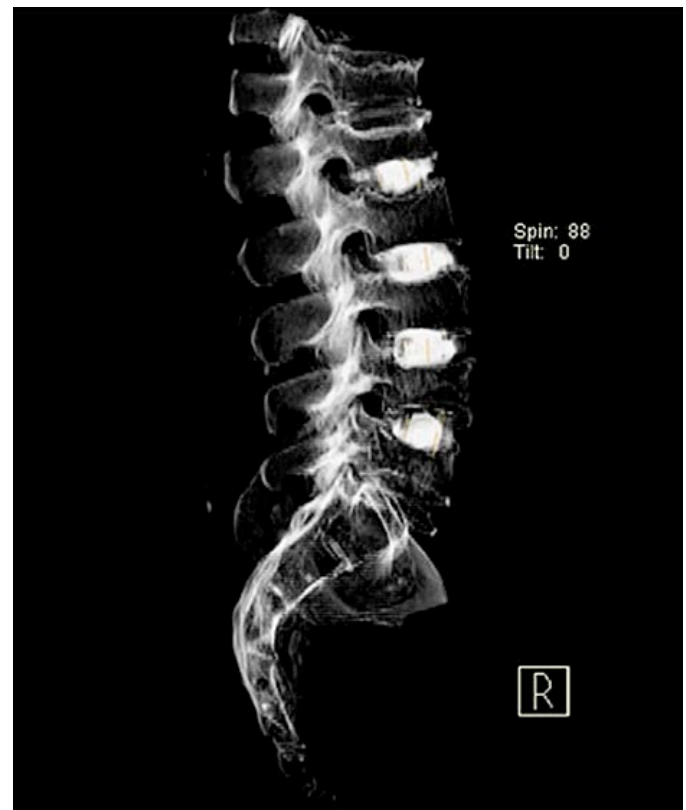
3-D CT-scan image of post Infill injection of graft material.
